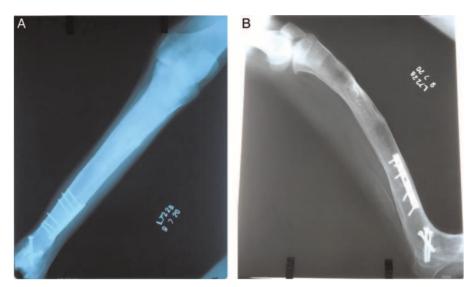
Radiograph 10 yr after surgery showing well-incorporated bone. Anteroposterior (A) and lateral (B) views.
